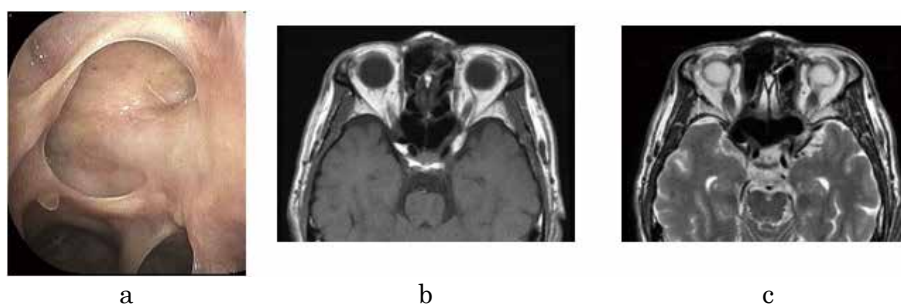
Postoperative endoscopic view of the left-sided posterior ethmoid sinus (a) and MRI scans of T1-weighted image (b) and T2-weighted image (c) showing no recurrence of AIFRS.
